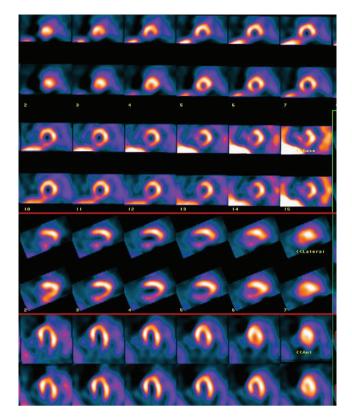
123I-mIBG SPECT, upper row of slices — 15 minutes post radiotracer injection, lower row — 4 hours post radiotracer injection
